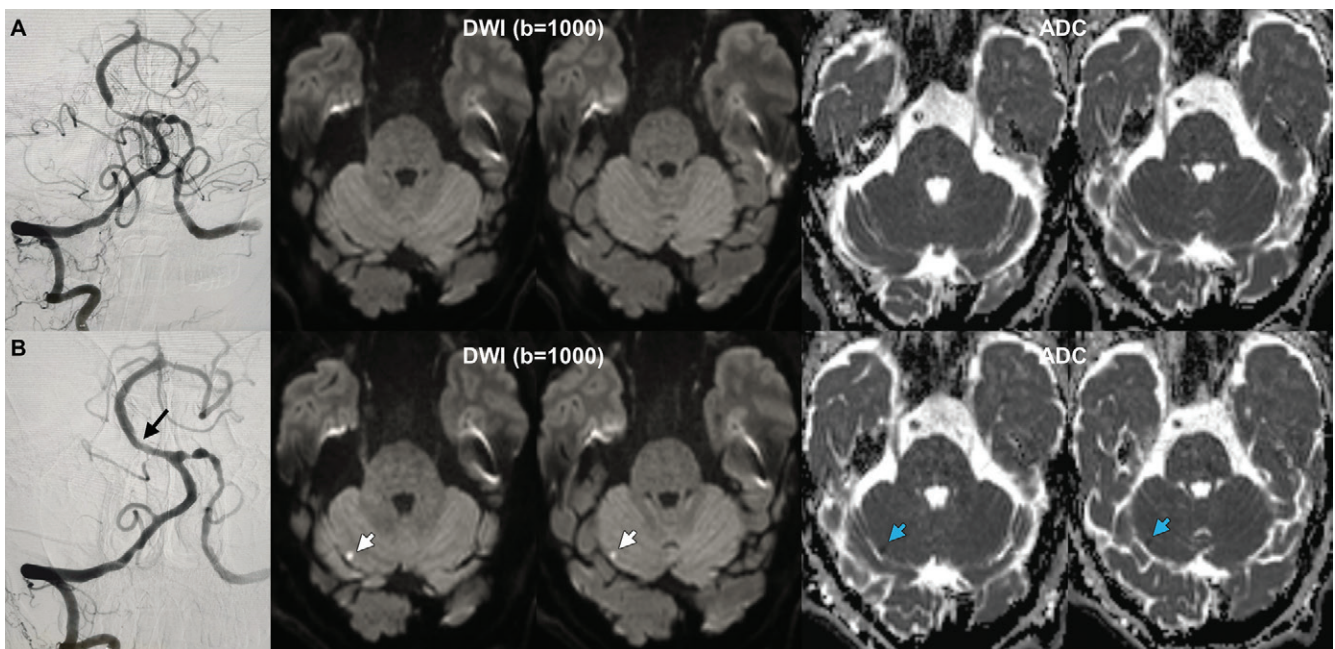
Images in a 68-year-old man with severe basilar artery stenosis who presented with recurrent dizziness for 3 months. (A) Image from digital subtraction angiography (left) shows severe stenosis at the proximal segment of the basilar artery. No new ischemic brain lesion is seen on the pretreatment diffusion-weighted imaging (DWI) scans and apparent diffusion coefficient (ADC) maps. The stenosis lesion was dilated with a 2.5 × 9-mm balloon. (B) Image from digital subtraction angiography (left) shows that the degree of stenosis of the proximal basilar artery was markedly improved after balloon angioplasty (arrow). Posttreatment DWI scans and apparent diffusion coefficient maps show small cerebellar cortical new ischemic lesions (arrows), which were located in the territory of the treated artery.
